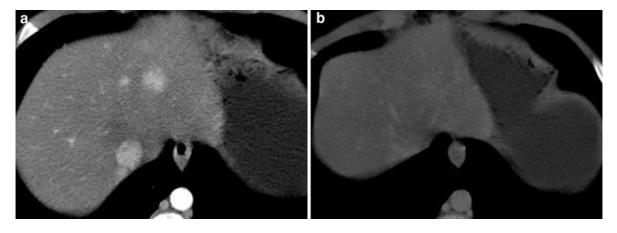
Large regenerative nodules. a Transverse contrastenhanced CT image during hepatic arterial phase demonstrates two liver lesions showing uniform vivid enhancement. b Corresponding contrast-enhanced CT image during hepatic venous
